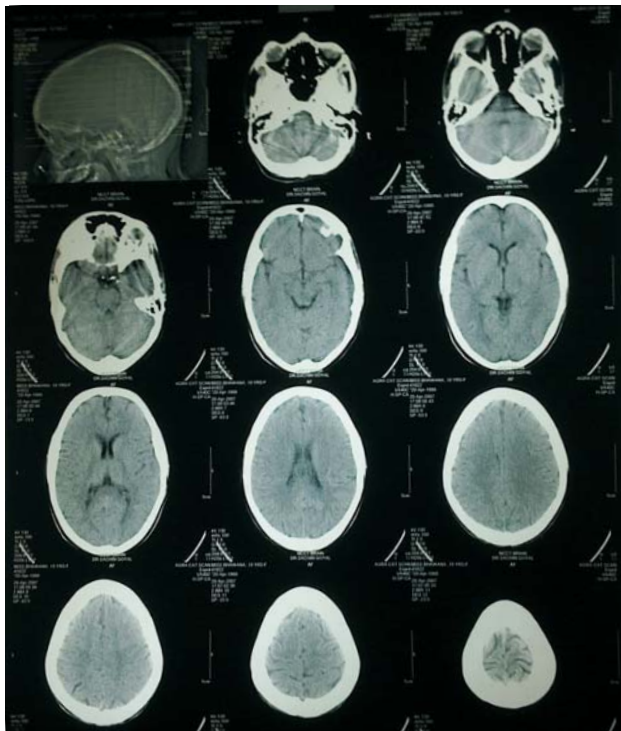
CT Head-normal done to rule out any tumour leading to oncogenic osteomalacia.
